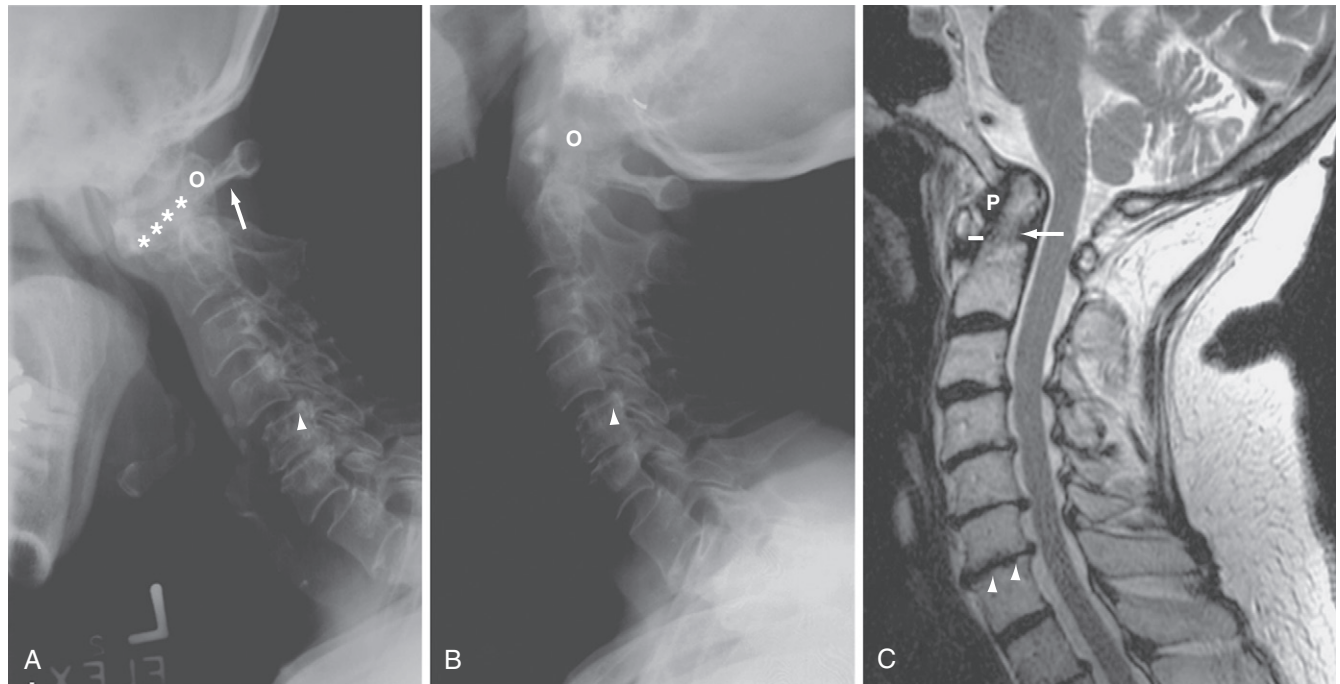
Cervical spine in rheumatoid arthritis (RA) (x-ray). A and B, Anterior atlantoaxial subluxation in RA. A, Lateral x-ray in flexion shows severe anterior atlantoaxial subluxation with a wide anterior atlantodental interval (*asterisks*) and a decreased posterior atlantodental interval (*arrow*). B, Almost complete reduction of subluxation is noted on the lateral view in extension. There also is subaxial subluxation at the level of C4-C5 (*arrowhead*) with erosive changes in various facet joints. O, odontoid. C, T2-weighted sagittal magnetic resonance (MR) image in RA shows low signal peri-odontoid pannus (P). The odontoid process appears irregular secondary to erosions (*arrow*). The atlantodental distance shows mild widening (*solid line*). There also is vertical subluxation without signs of cord compression. The anterior subarachnoid space is compromised by disk protrusions at multiple levels. Small erosions (*arrowheads*) are seen at the vertebral end plates at the C6-C7 level.
